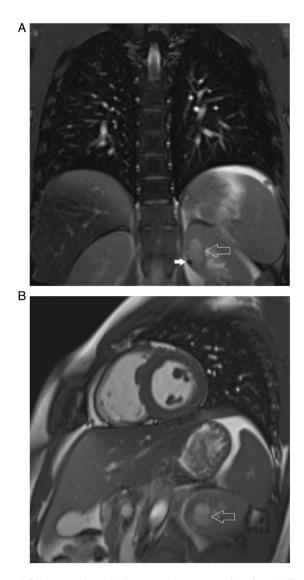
Lesion as observed using magnetic resonance imaging. (A) Frontal plane and (B) sagittal plane. The images indicate an incidentally revealed pathologic lesion of the left kidney (hollow arrow) containing a small solid component adjacent to its wall (filled arrow). The lesion is well-demarcated and shows high signal intensity on T2-weighted imaging.
